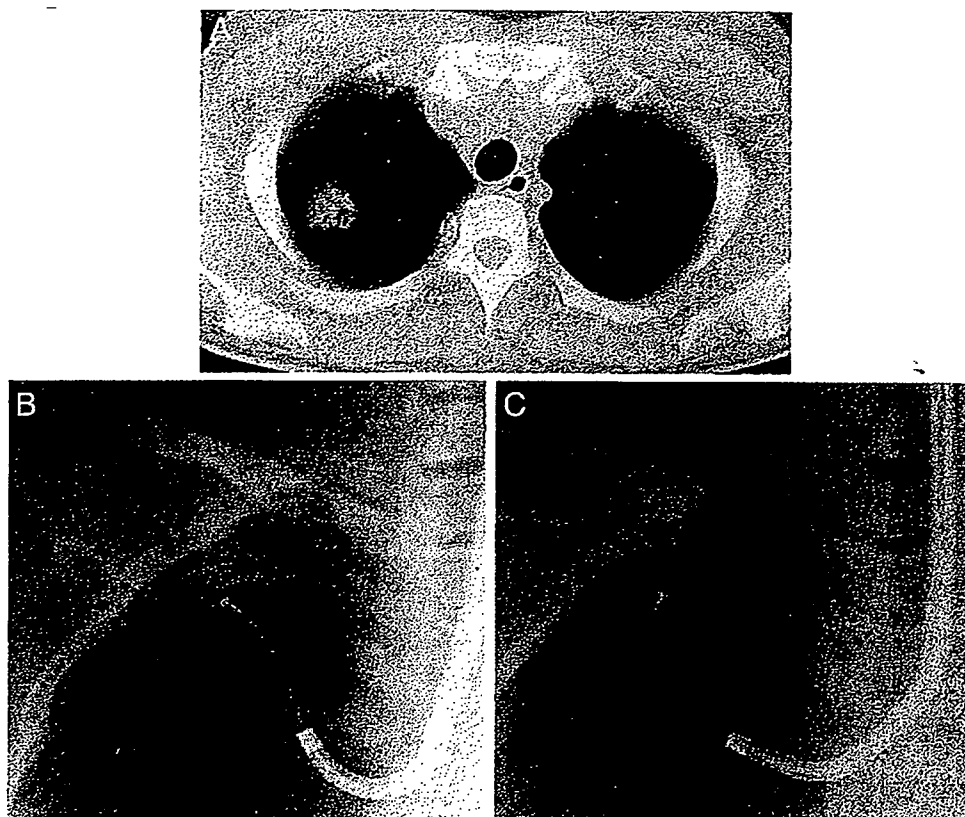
Case 1. A tuberculoma. *Top, A:* a chest CT scan reveals a coin lesion in the right upper lobe. *Bottom left, B:* a bronchoscopic image shows a standard forceps approaching a tumor through the right B1a. *Bottom right, C:* bronchoscopic image shows the STAF approaching the tumor. It forms a CS (*ie*, J-shape).
